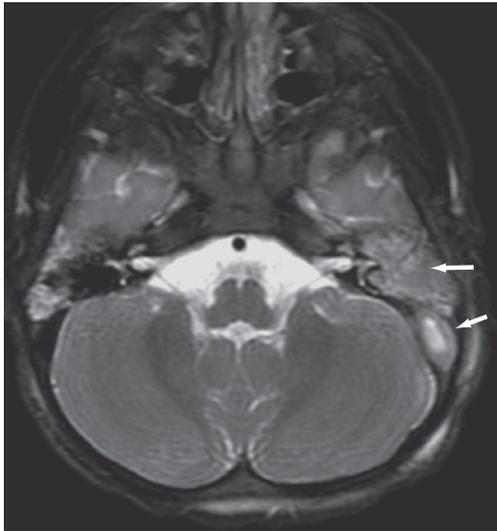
Lateral sinus thrombosis. Magnetic resonance imaging shows a thrombus in the lateral sinus (short arrow) with accompanying mastoiditis (long arrow). (Courtesy of Drs. Martin Pomper and Dima Hammoud, Johns Hopkins University.)
